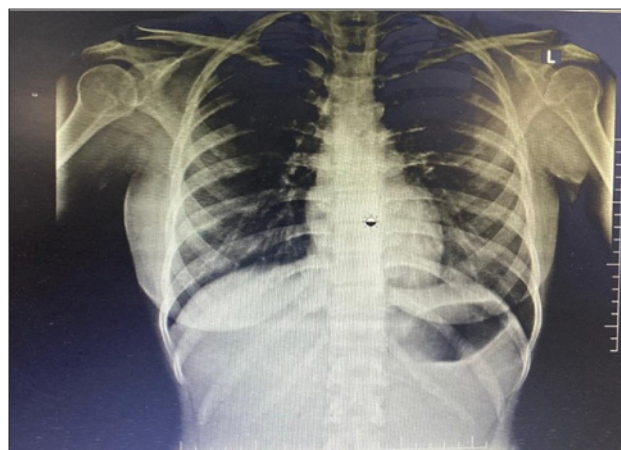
PA View of X-Ray after Discharge during Follow up
